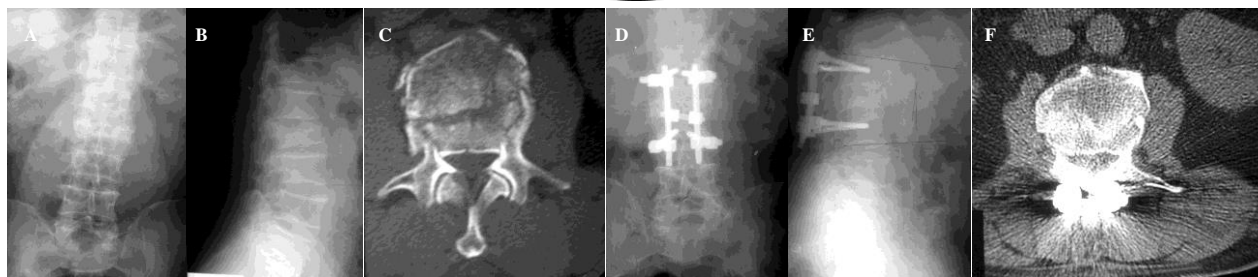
Case example of 59 years-old male patient with L2 vertebra burst fracture (A: Preoperative antero-posterior view, B: Preoperative lateral view, C: Preoperative computed tomography section, D: Postoperative 1-year antero-posterior view, E: Postoperative 1-year lateral view, F: Postoperative 1-year computed tomography section)
